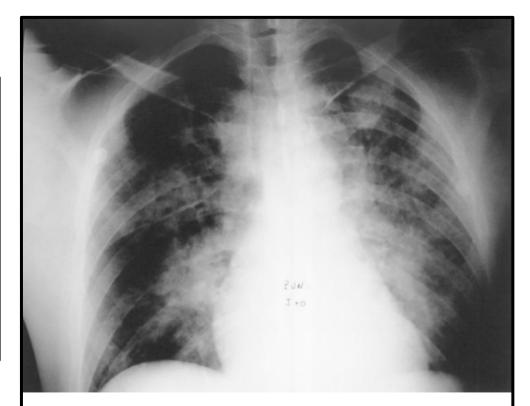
Chest radiograph of a patient with HAPE (Hultgren stage IV) that occurred at moderate altitude (maximum altitude reached, 2,200 m).
